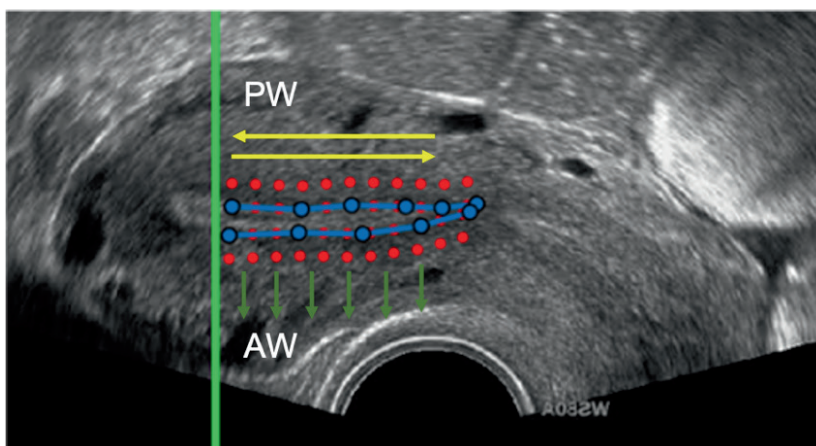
2D Transvaginal ultrasound image of uterus in midsagittal section.
